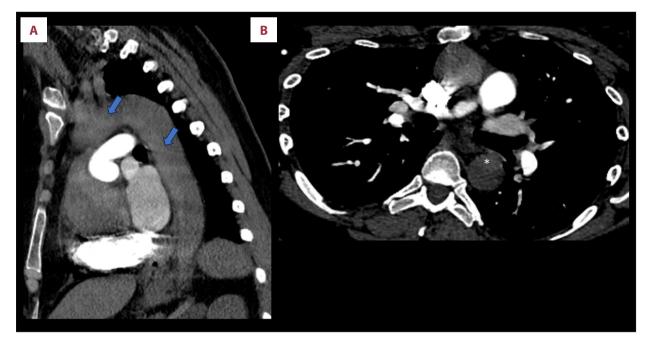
Chest computed tomography scan with contrast. (A) Sagittal chest computed tomography scan with contrast administration timed to evaluate the pulmonary arteries. No pulmonary embolic disease was detected. Higher density of blood along the aortic arch and descending aorta (arrows) was appreciated. The fetus was intentionally not imaged to minimize radiation exposure. (B) Axial chest computed tomography scan with contrast administration timed to evaluate the pulmonary arteries showing the true lumen of the descending aorta dissection (star).
